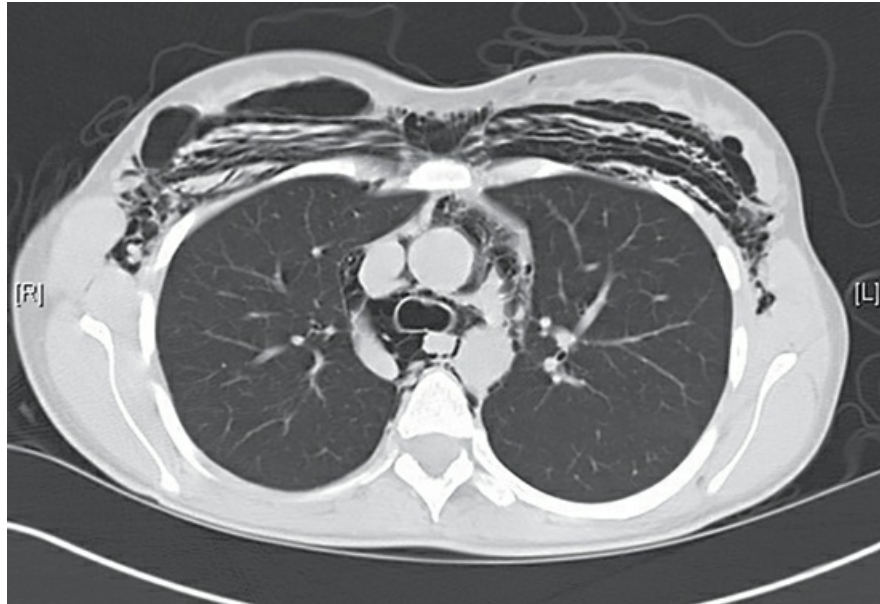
Chest computed tomography scan shows air within the mediastinum (pneumomediastinum) and air in subcutaneous tissues of the anterior chest wall (subcutaneous emphysema).
